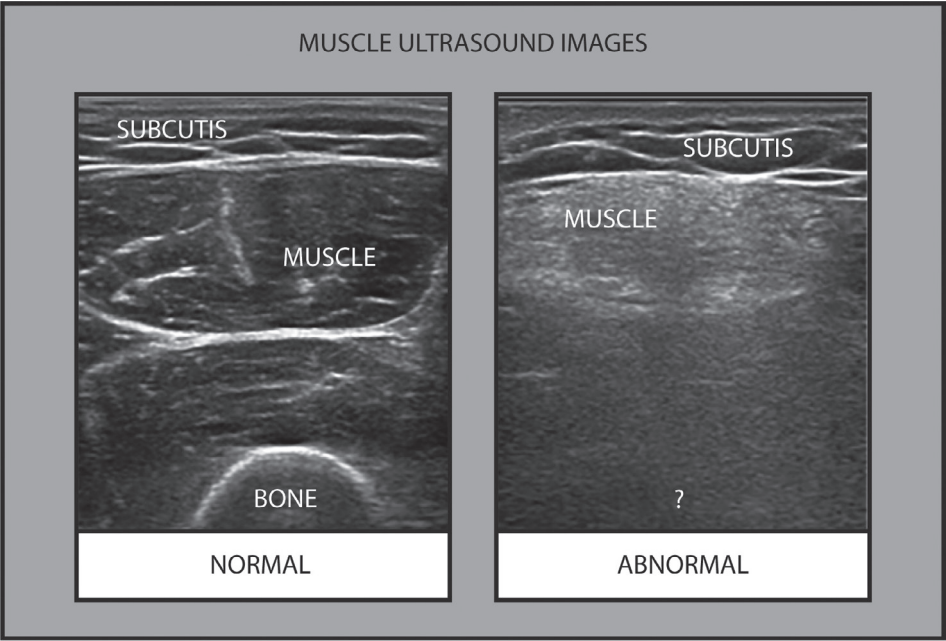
muscle ultrasound images of a rectus femoris muscle in a healthy (left) individual and an individual with known Duchenne muscular dystrophy (right).
